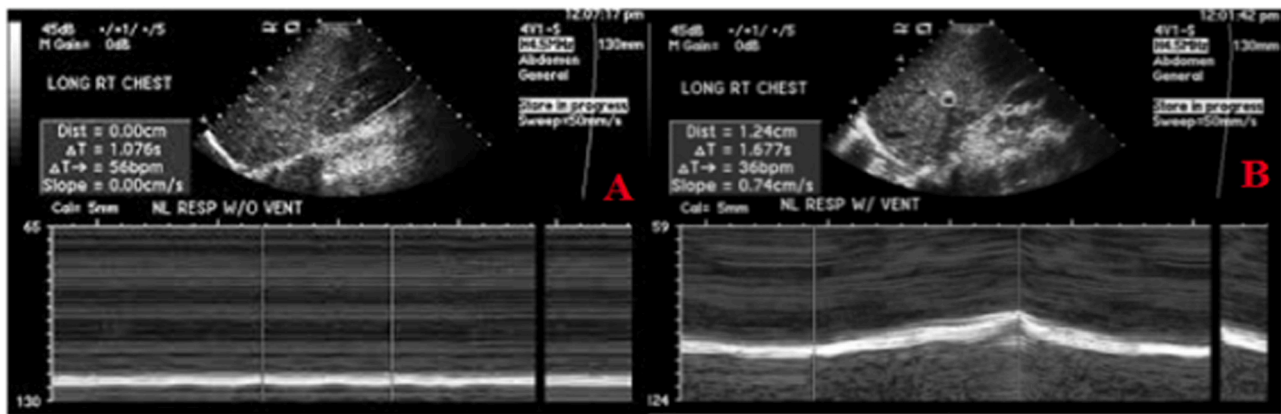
(A). M-mode diaphragm ultrasonography during a breathing trial without mechanical ventilation in a subject with no spontaneous respiration. M-mode diaphragm ultrasonography with pacer amplitude at 1.0, 1.5, and 2.0 with this diaphragm excursion was zero. Note the flat white line indicating no movement of the diaphragm. (B). M-mode diaphragm ultrasonography during a trial with mechanical ventilation in a subject with spontaneous respirations. M-mode diaphragm ultrasonography with pacer amplitude at 1.0, 1.5 and 2.0 with the diaphragm excursion 0.74 cm, 1.10 cm, and 1.24 cm correspondingly. Note the white line indicating movement of the diaphragm.
